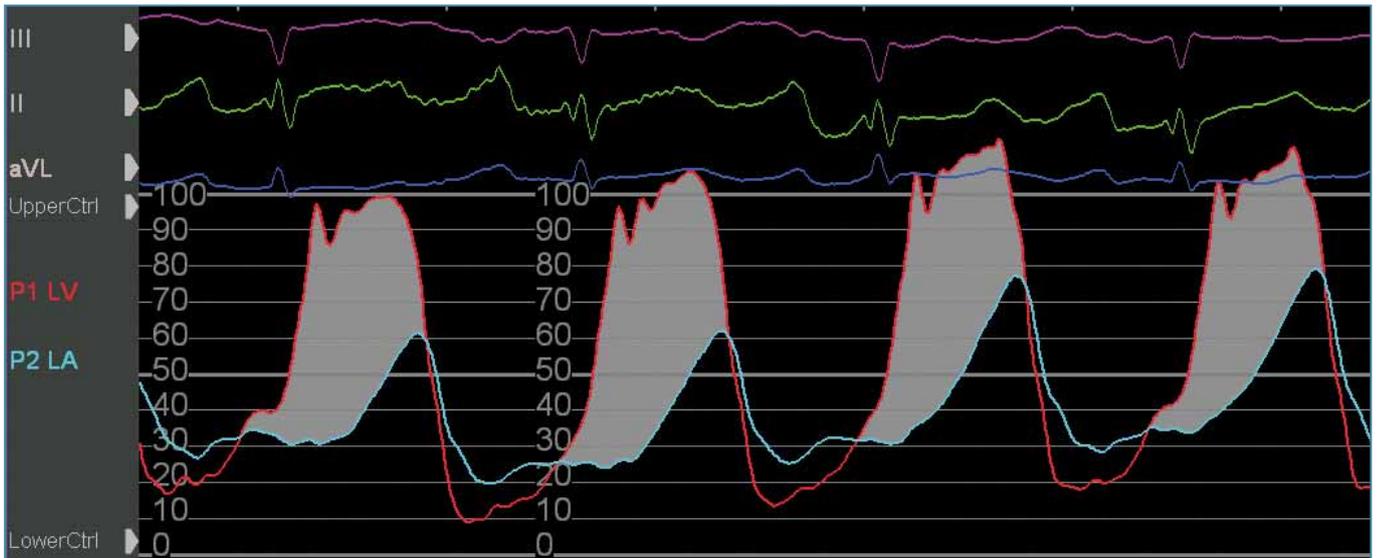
Simultaneous haemodynamic tracing of LV (red) and LA (blue) pressures in the setting of acute severe MR. Note the large atrial V-wave. The shaded area represents the effect that the large V-wave has on degrading the systolic LV-LA pressure gradient leading to V-wave cut-off on the transmitral Doppler trace. Compare this to Figure 5 in a patient without acute severe MR where the LV-LA systolic gradient is maintained throughout systole.
